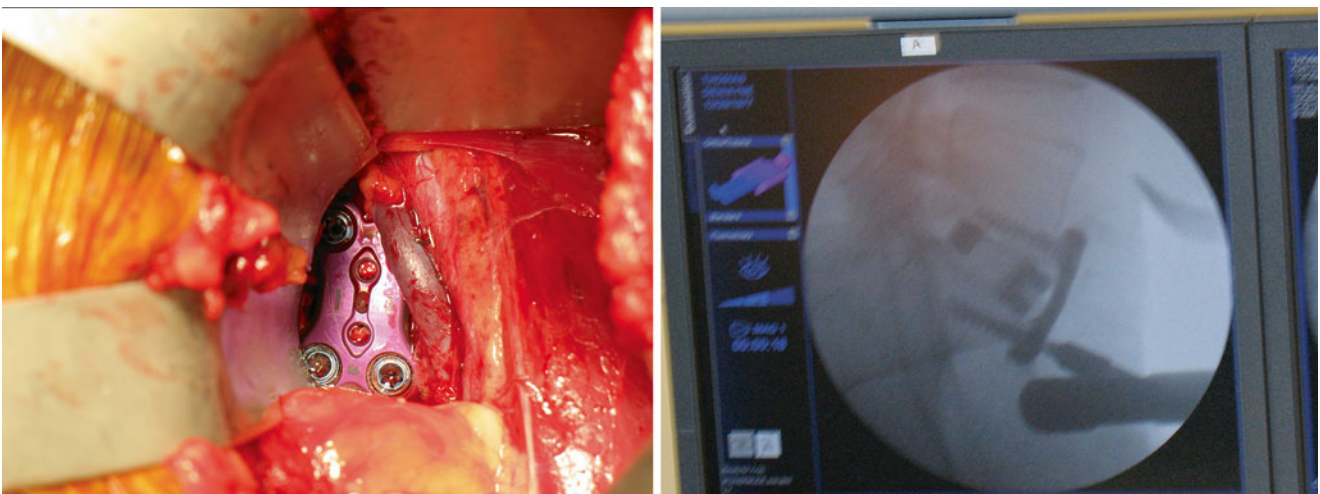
Intraoperative image (*left*) demonstrating position of plate and secured to the L5–S1 vertebral bodies with fixation screws. Intraoperative lateral x-ray (*right*) displaying the interbody cage and anterior plate of L5–S1
